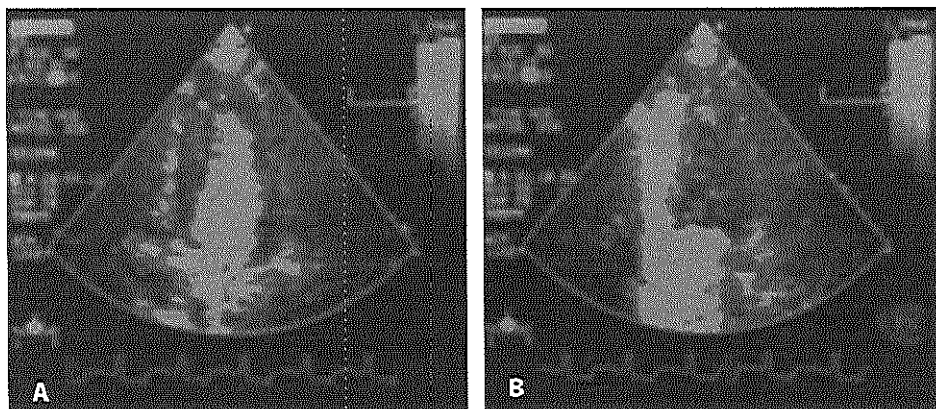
Echocardiographic contrast perfusion images in a patient on Tandemheart(r) circulatory support. Panel A: low circulatory support (high wall tension, poor myocardial perfusion, contrast remains in the ventricle cavity). Panel B: Full circulatory support with effective unloading of the left ventricle (low wall tension, good myocardial perfusion).
